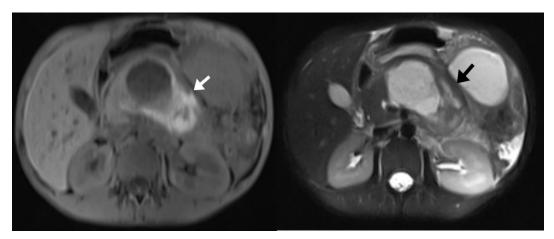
a, b. MRI of hemorrhagic pancreatic pseudocyst in the pancreatic parenchyma. The periphery of the pseudocyst was hyperintense on T1W images (a) and hypointense on T2W images (b) consistent with subacute hemorrhage (arrows).
